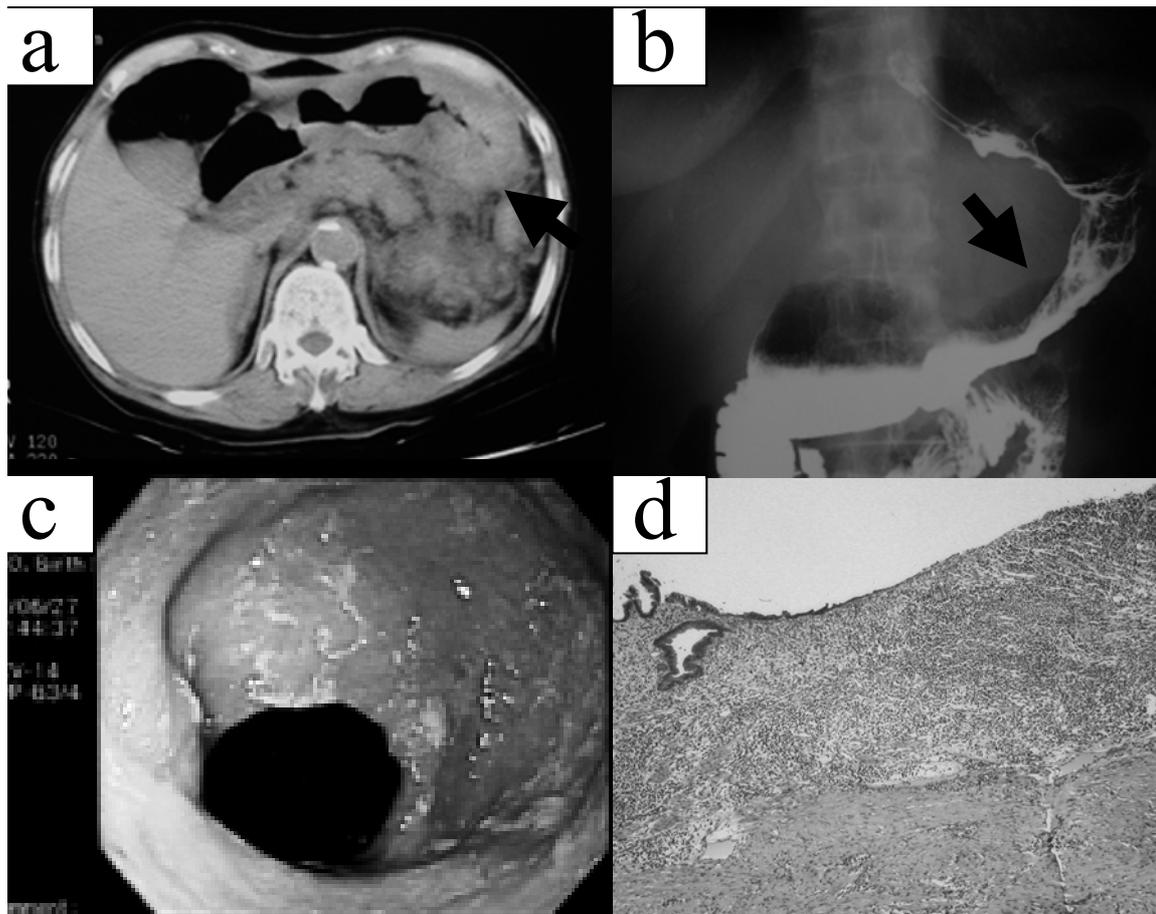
Abdominal CT showed diffuse and irregular thickening of the stomach body wall (arrow). b: Barium examination of the upper gastrointestinal tract revealed a marked large irregular filling defect involving the entire gastric wall (arrow). c: Endoscopy showed edematous and reddened gastric mucosa with a stricture in the gastric body. d: A gastric section showing diffuse inflammatory swelling of submucosa with involvement of the muscularis. (original magnification, x100)
